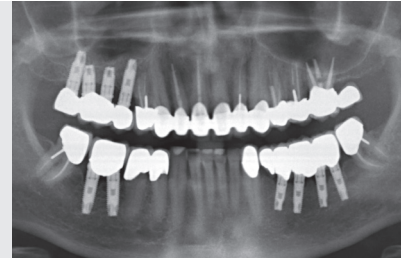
Preoperative X-ray showing inadequate root fillings, bone atrophy around implants and a questionable number of implants
